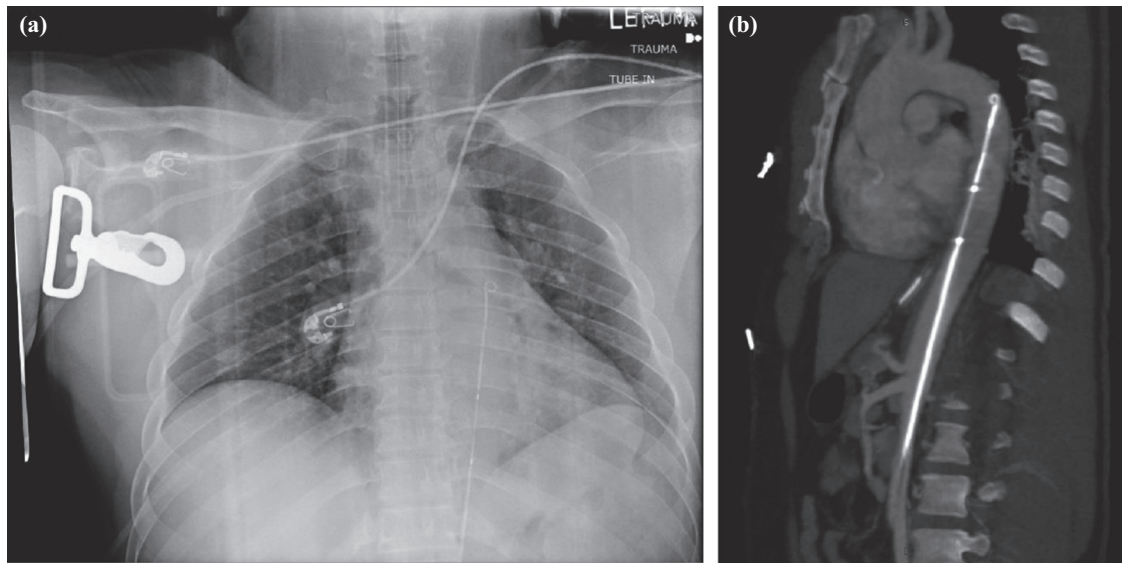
Portable chest x-ray (a) and CT chest (b) after Zone 1 ER-REBOA™ catheter placement.
